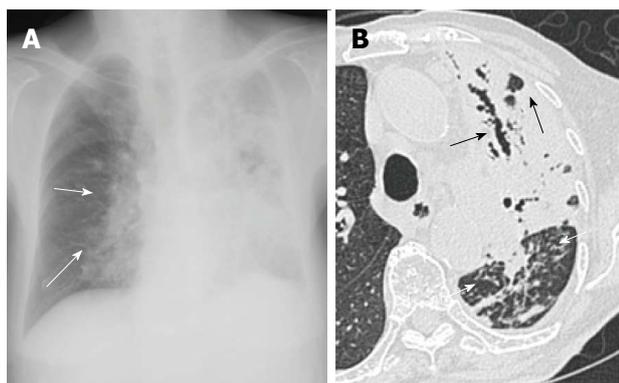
Tuberculous pneumonia in a woman in her 80s. A: Chest radiograph shows extensive consolidations with poor aeration of the left lung and peribronchovascular consolidations of the right lung (arrows); B: Thin-section computed tomography reveals extensive consolidation with air bronchograms and cavities in the left upper lobe (black arrows). Note that the bronchi in the consolidation are dilated. Dense centrilobular nodules are seen in the left lower lobe (white arrows).
